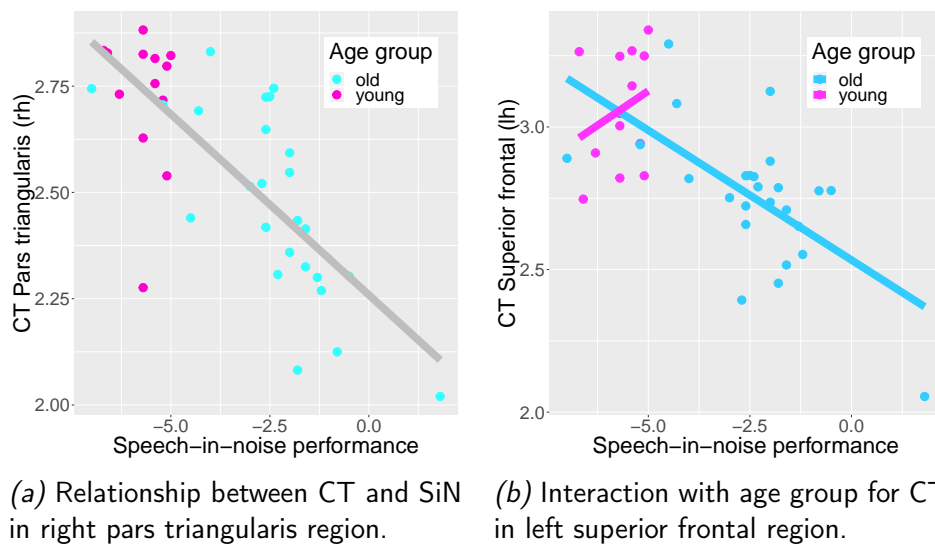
Significant relationships between CT in the regions and speech in noise performance.
